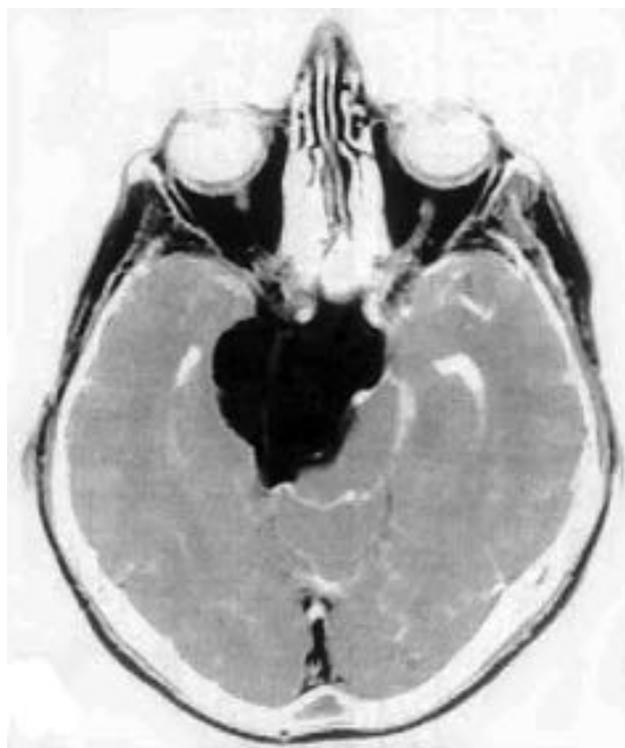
Axial T1-weighted magnetic resonance imaging after gadolinium injection demonstrating a large petroclival meningioma with brain stem compression and displacement of the basilar artery as well as supratentorial extension into the middle fossa. Reproduced with permission from Liu JK, Couldwell WT. Petrosal approach for resection of petroclival meningiomas. In: Badie B, ed. *Neurosurgical Operative Atlas 2E: Neuro-oncology*. New York, NY: Thieme; 2007.³²
